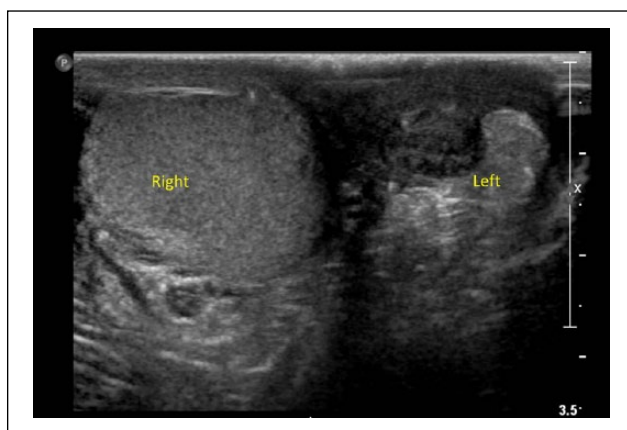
(b). Repeat ultrasonographic assessment of the same patient, done postoperatively at 2 months, showing complete atrophy of the affected left testis.
